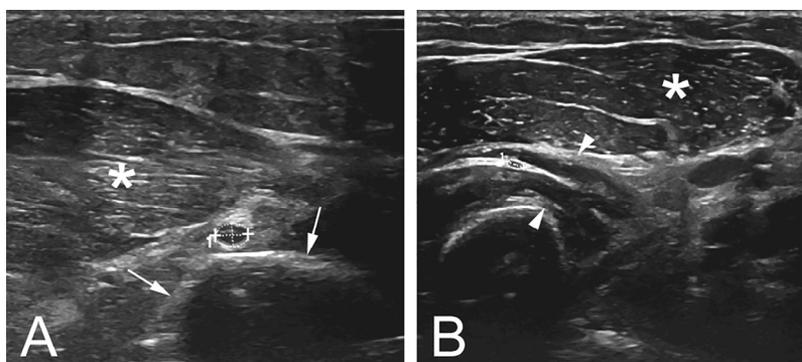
Normal high-resolution ultrasonography (HRUS) findings. (A) Radial nerve at the spiral groove (*lateral head of triceps brachii muscle). (B) Radial nerve in the supinator canal (<supinator muscle, *brachioradial muscle).
